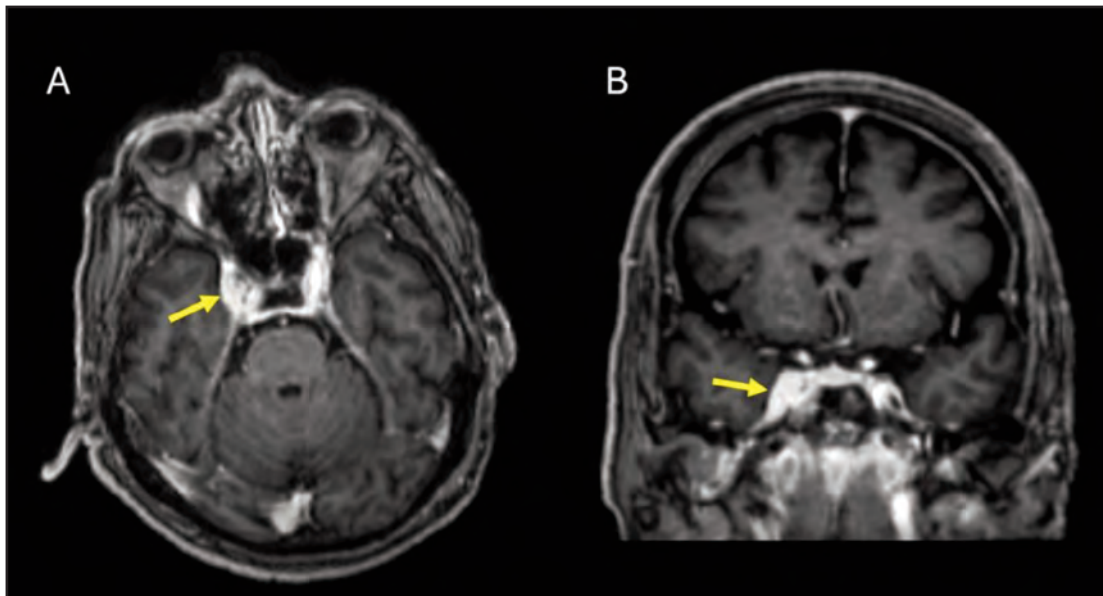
MRI of the brain in T1-weighted post gadolinium in axial (a) and coronal (b) views showed a right cavernous sinus mass with enhancement post-contrast (yellow arrow)
